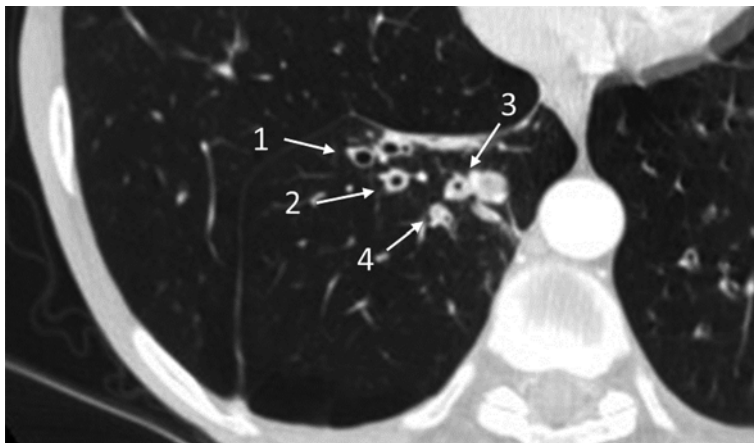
Transverse section of computed tomography of the lung (detail of right lower lobe). Arrows indicate (1) mild bronchial wall thickening and bronchiectasis, (2) moderate bronchial wall thickening and bronchiectasis, (3) marked bronchial wall thickening, and (4) mucus plugging (Images kindly provided from Prof. Berthold. Paediatric Radiology, Hanover Medical School, Germany, EU)
